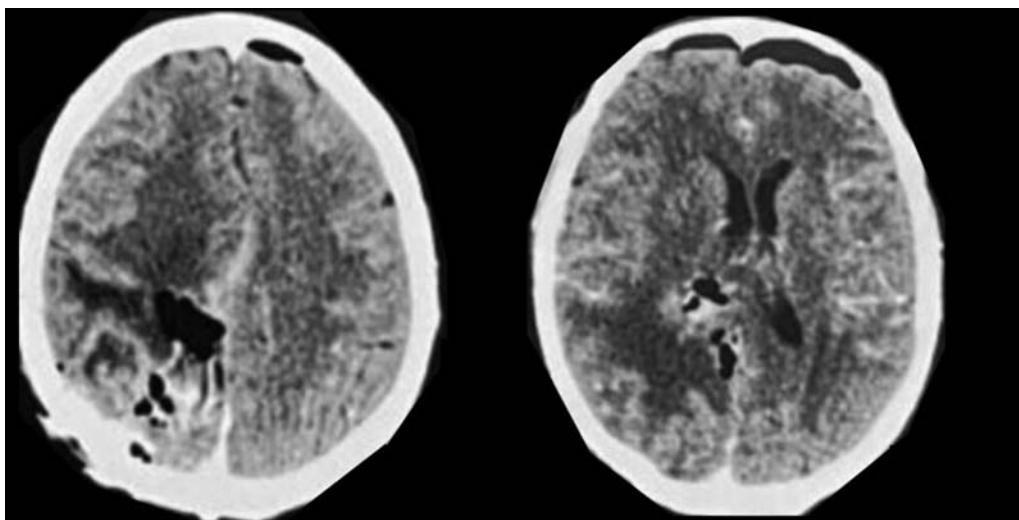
Postoperative axial cranial computed tomography scan showing gross total resection of the tumor.
